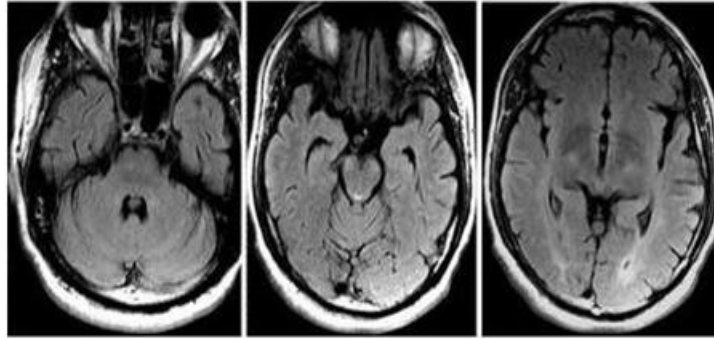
The second brain FLAIR MRI showing disappearance of most lesions
